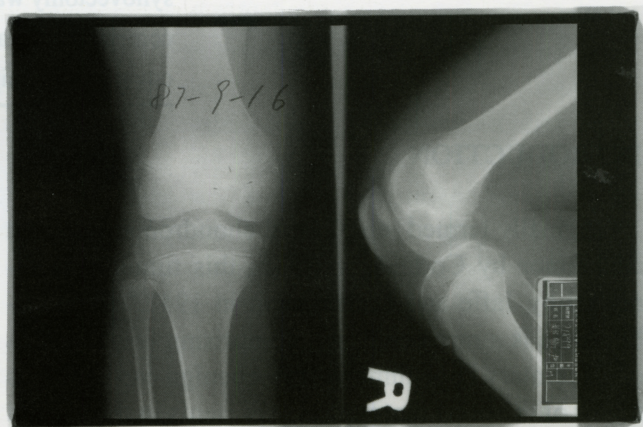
Anteroposterior and lateral radiographs taken 4 months after surgery. The size of the lesion has shrunk.
